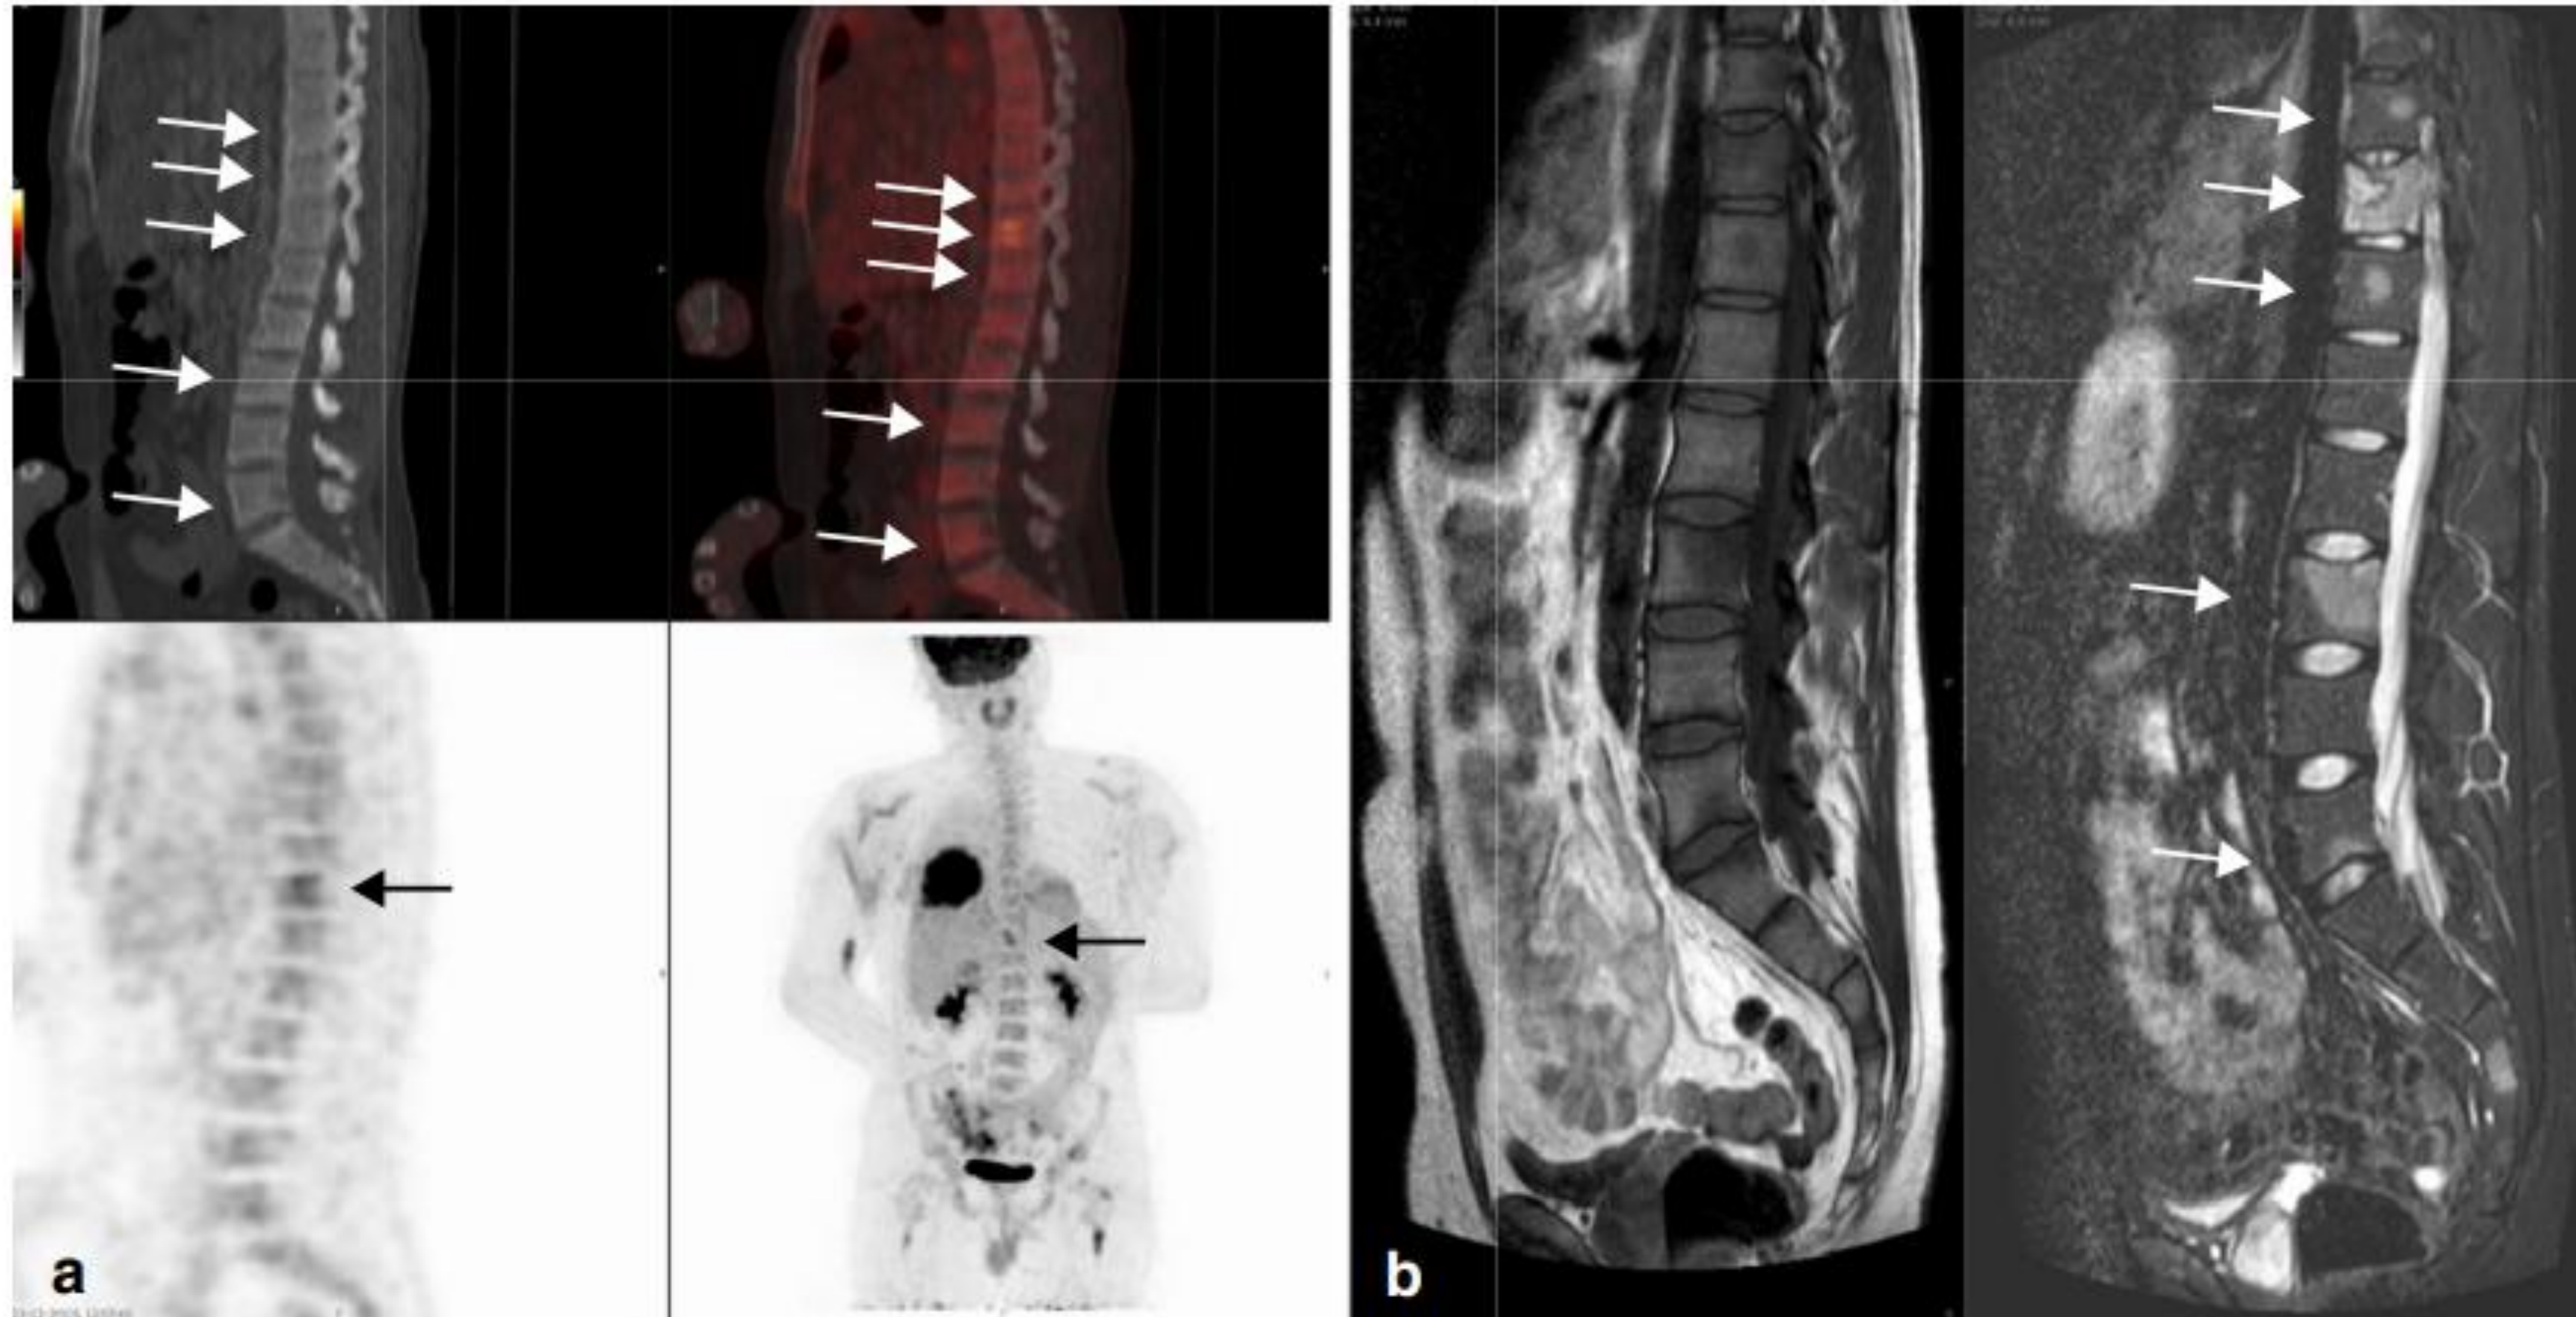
False-negative lesions on ¹⁸F-FDG PET-CT (arrows). A 23-year-old man presenting with metastatic Ewing sarcoma of the right seventh rib. Images obtained at diagnosis, before the start of treatment. a ¹⁸F-FDG PET-CT showing increased ¹⁸F-FDG-uptake at the eleventh thoracic
